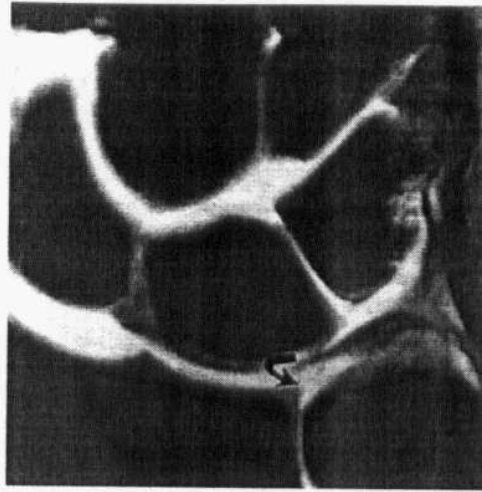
Traumatic avulsion of the radial attachment of the TFC as described in class ID lesions. Note the exposed articular cartilage at the radial sigmoid notch. Fluid communicates between the radiocarpal and distal radioulnar compartments (curved arrow) on this fat-suppressed T1-weighted coronal MR arthrographic image. The LT ligament is absent(Quoted from Stoller and Brody, 1997).
